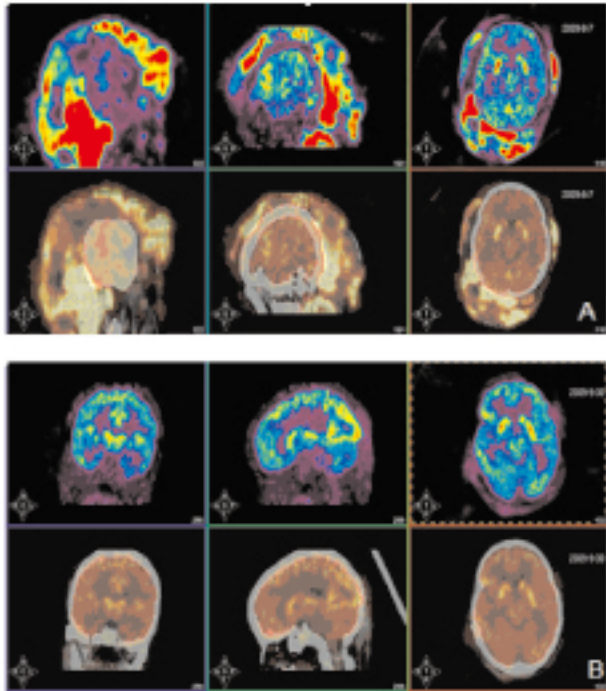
Change of head lesions on PET/CT. FDG metabolism of skin lesions on head decreased, the tumor was shrinking over 90%. A: Before chemotherapy (Aug.7th, 2009); B: After chemotherapy (Sep. 30th, 2009).
